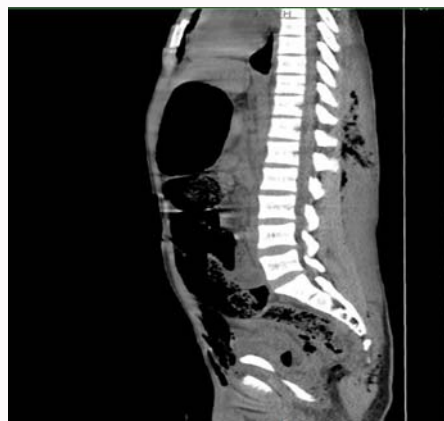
Non contrast CT with Sagittal reconstruction thoraco-lumbar compression fracture.
